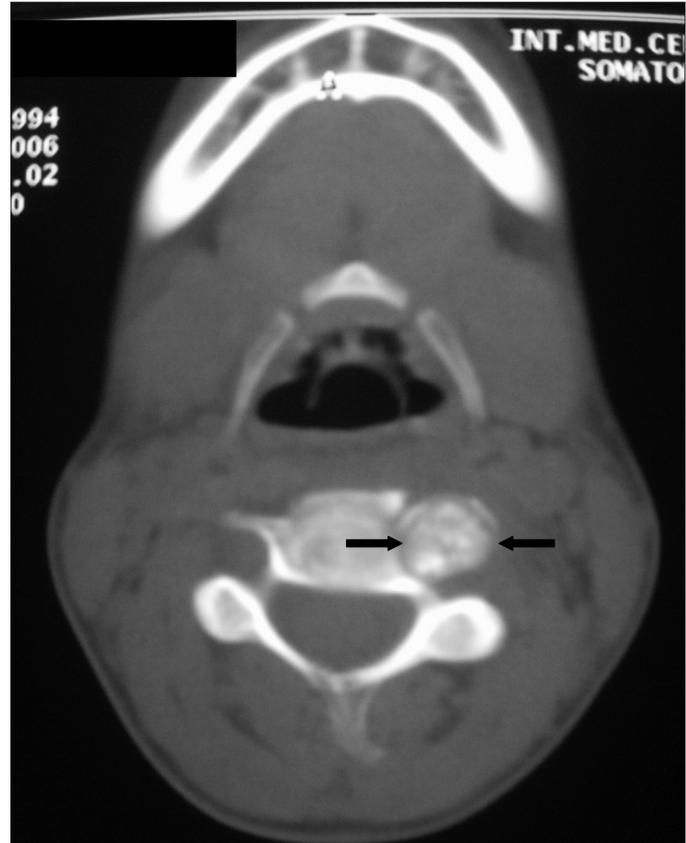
CT image of the cervical vertebrae; a heterogeneously sclerotic, nodular bony lesion in the transverse process of the fourth cervical vertebrae (arrows).
